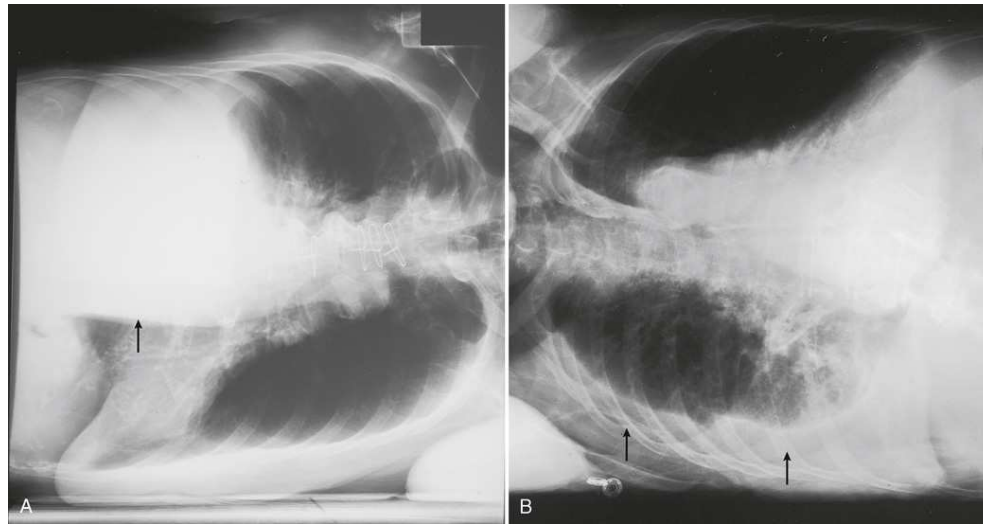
Mobile AP chest radiographs performed in lateral decubitus positions in critically ill patients. (A) Left lateral decubitus position. The patient has a large right pleural effusion (*arrow*) and no left effusion. The complete left side of thorax is visualized because of elevation on a block. (B) Right lateral decubitus position. The patient has a right pleural effusion (*arrows*), cardiomegaly, and mild pulmonary vascular congestion. The complete right side of thorax is visualized because of elevation on a block.
